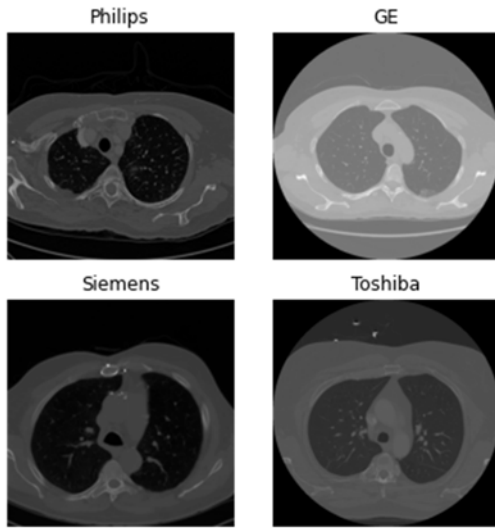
Example of CT slices from the LIDC-IDRI dataset.
